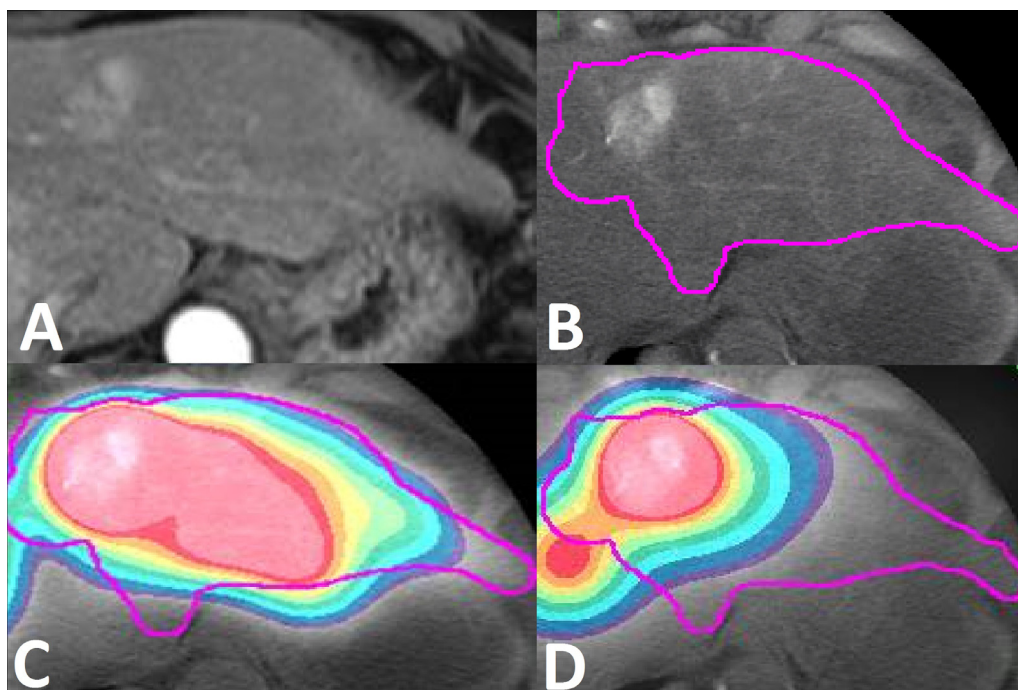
Arterial phase MRI demonstrates a single hepatocellular carcinoma which abuts the central left bile ducts (A). Contrast enhanced cone beam CT demonstrated supply from multiple segment 2 and 3 non-selectable arteries (B). Tc-MAA SPECT-CT shows a relatively large portion of uninvolved liver will be treated if both segments are treated (C). Post TARE with peripheral gelatin slurry administration Bremsstrahlung SPECT-CT demonstrates reduction in all isodose thresholds increasing tumor dose conformity and sparing uninvolved liver (count threshold: count reduction = 40%:14.7%, 20%:41.1%, and 5%: 7.6%) (D).
